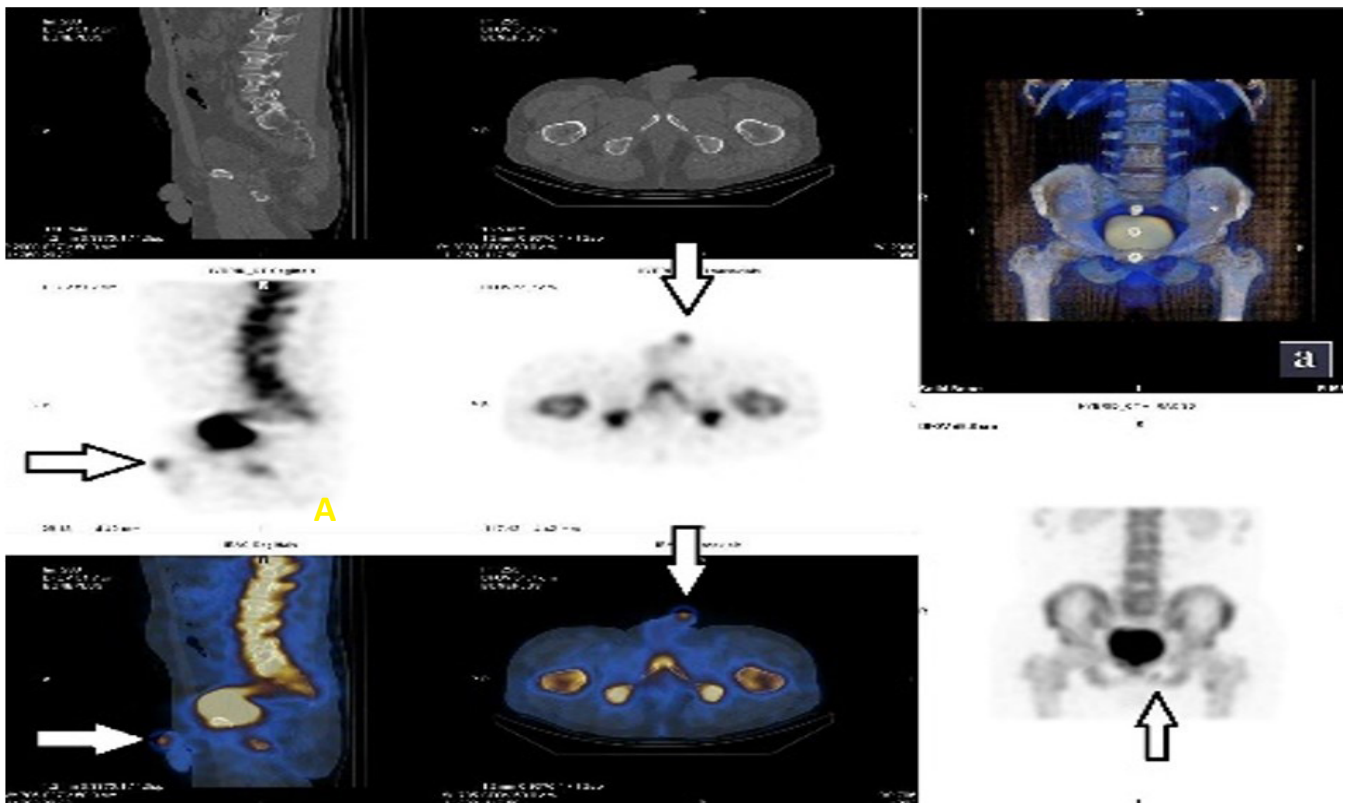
SPECT/CT images reveal that the focus of increased radiotracer activity observed on whole-body and static images corresponds to urine contamination on the glans of the penis (white arrow).
